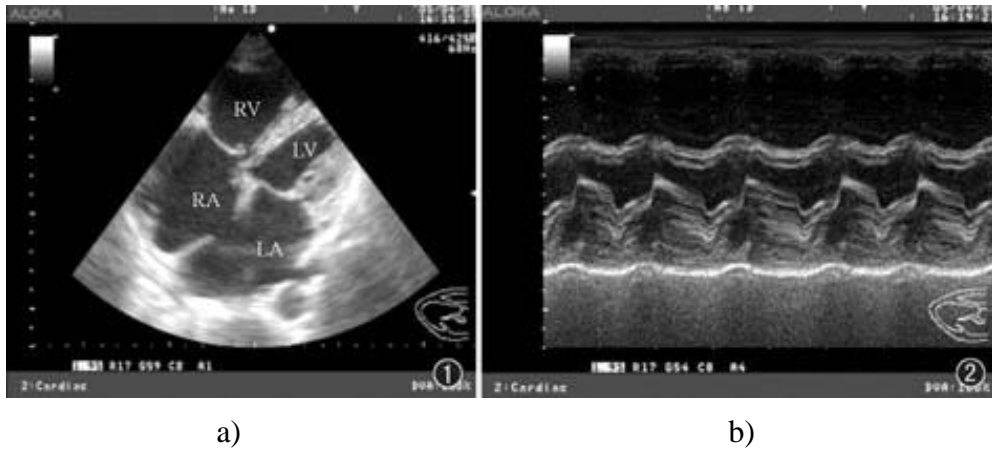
Echocardiographic Image of the four heart chambers: a) in B-mode b) in M-mode[49].
